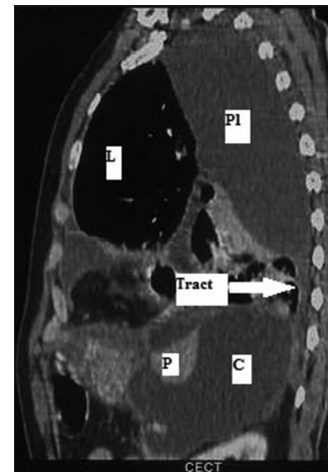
Contrast-enhanced computed tomography (chest and abdomen) revealed cyst in the tail of pancreas and tract (L: Lung, PI: Pleura, P: Pancreas, C: Cyst)
